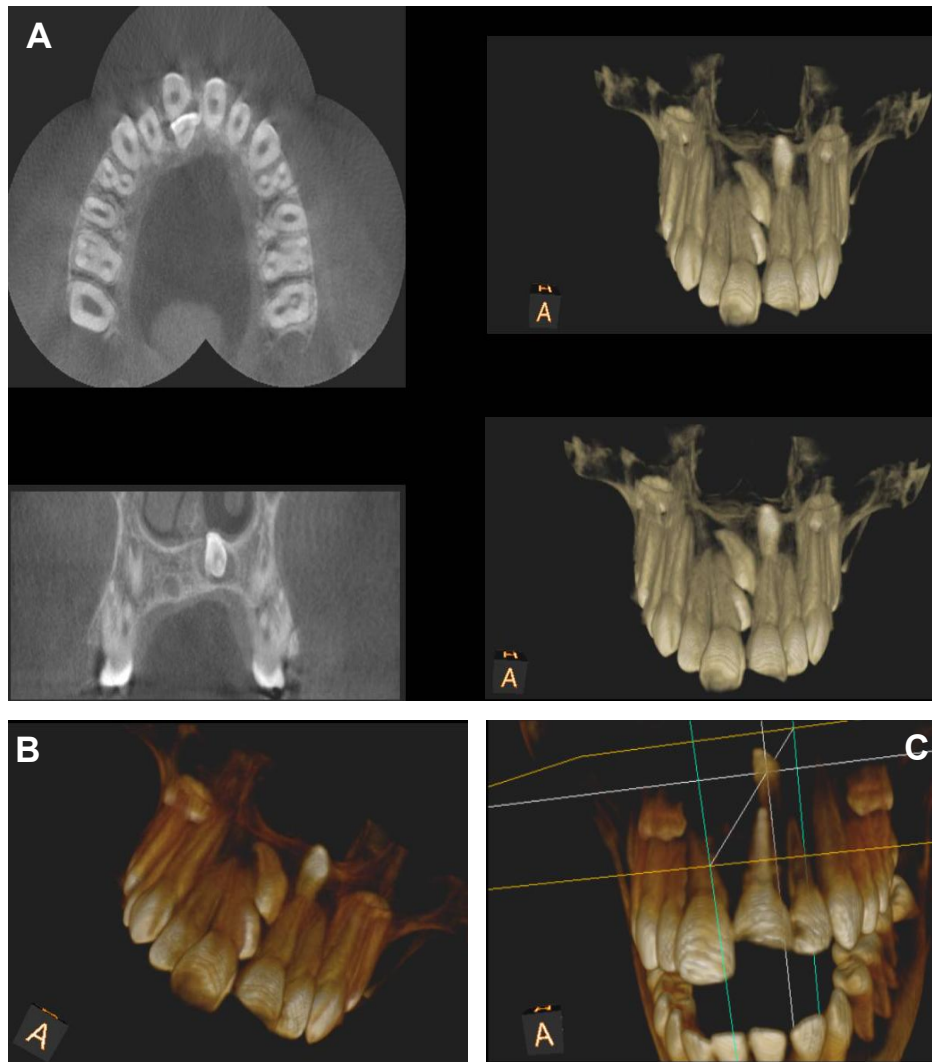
Three dimensional cone beam computed tomography (CBCT) showing selected slices for anatomical assessment and treatment planning of mesiodens; A)- Preoperative horizontal views, B)- Preoperative oblique view, C)- Postoperative CBCT confirming removal of two mesiodens, while leaving the third mesiodens in the place; anatomical lines have been drawn to show the depth of the mesiodens. The angulation of images in relation to the horizontal plane ["A" sign] is shown at lower left corner of each image
